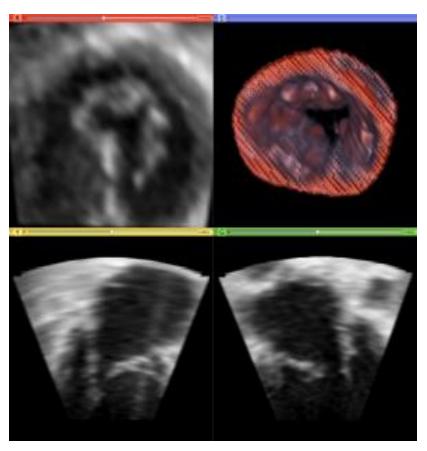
Volume rendering of a pediatric heart (case B) with axial, sagittal and coronal slice views. The annulus contour of the valve was determined from 2D slices taken from the ultrasound volume.
